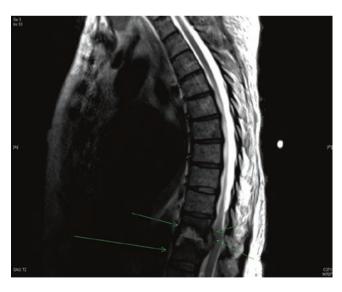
T2 sagittal MRI image of a 78-year-old female with a large ventral epidural abscess at the T11–T12 level, surrounded by green arrows. This extensive infection extends into the vertebral body and intervertebral disc. The patient, in contrast to the patient presented in this case study, presented with profound neurologic deficits
